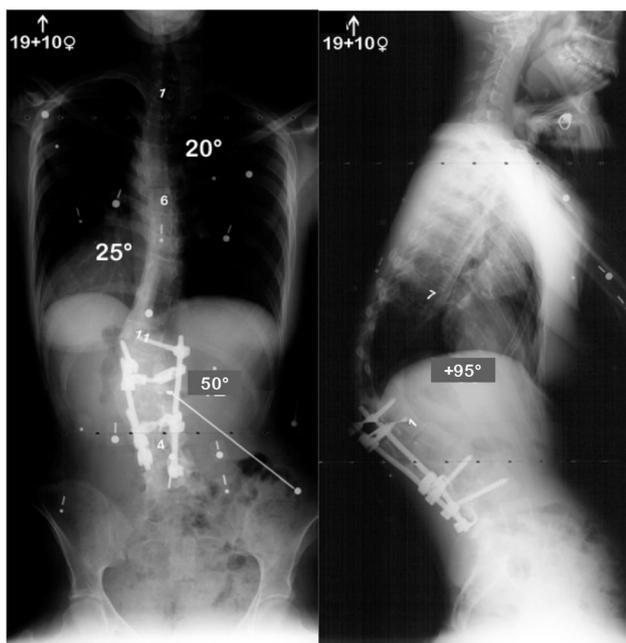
Upright X-rays of a 19-year-old female with a connective tissue disorder and thoracolumbar adolescent idiopathic scoliosis. She had previously undergone six posterior procedures and presented to us with severe thoracolumbar kyphosis
